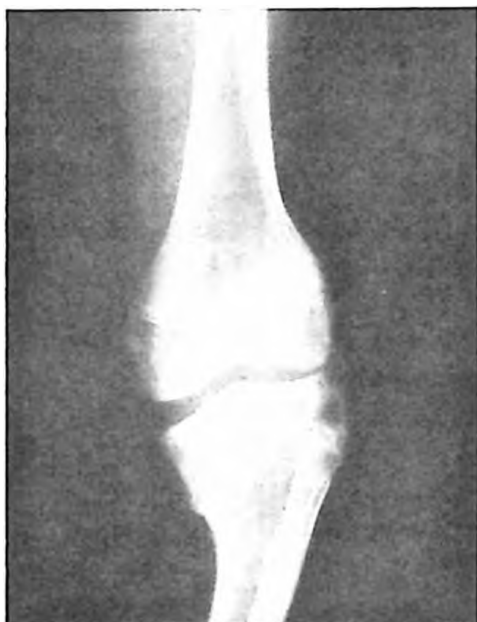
Anteroposterior (AP) weight-bearing X-ray of the left knee (Patient B).
